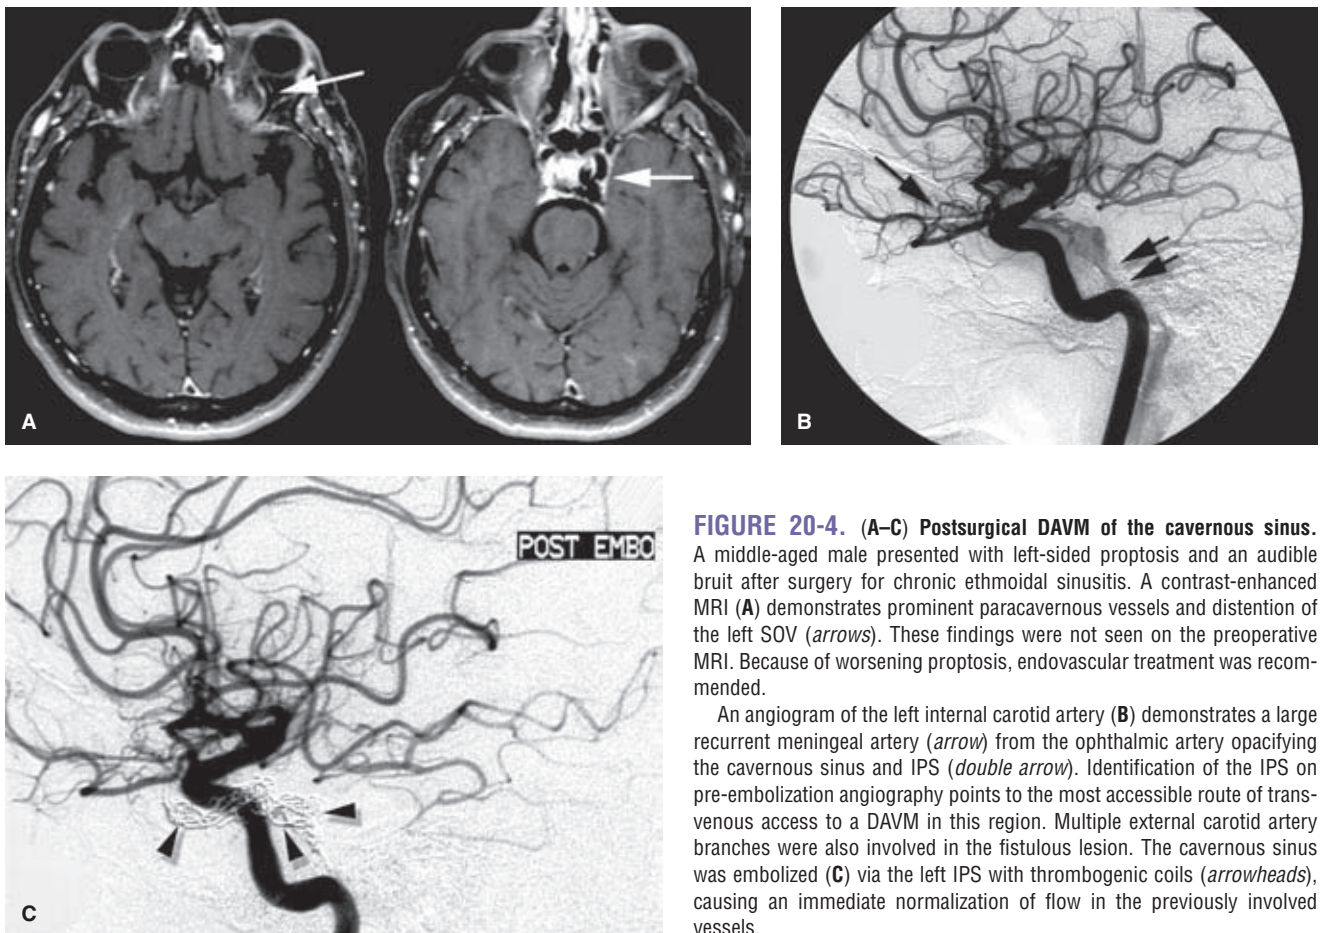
(A–C) Postsurgical DAVM of the cavernous sinus. A middle-aged male presented with left-sided proptosis and an audible bruit after surgery for chronic ethmoidal sinusitis. A contrast-enhanced MRI (A) demonstrates prominent paracavernous vessels and distention of the left SOV (arrows). These findings were not seen on the preoperative MRI. Because of worsening proptosis, endovascular treatment was recommended.
